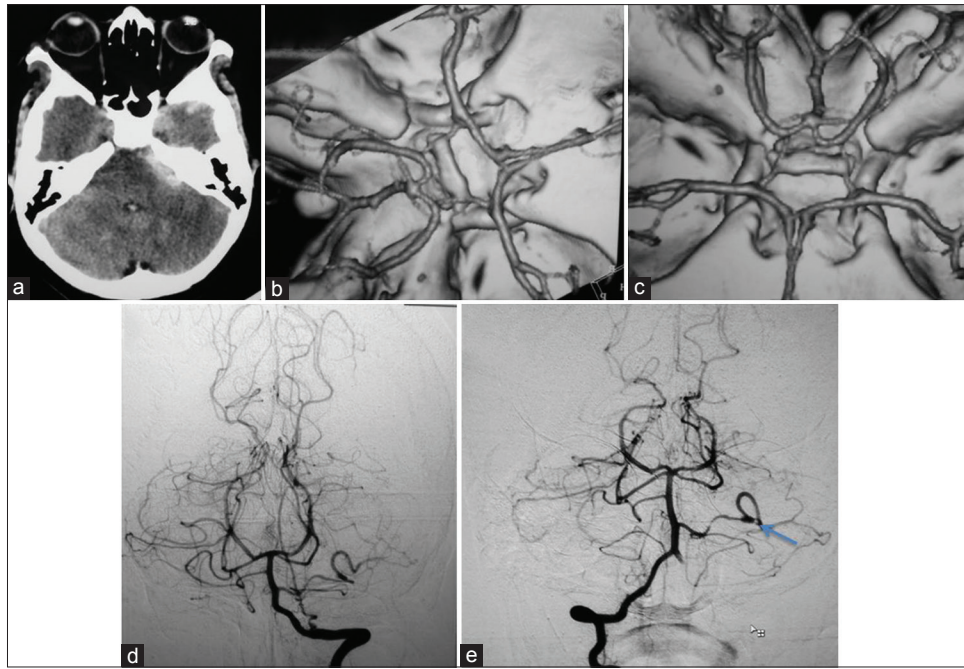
NCCT head showing moderate SAH in left cerebellopontine angle cistern (a), 3D-CTA brain showing no structural abnormality (b,c); Initial DSA Brain showing no aneurysm (d); Repeat DSA brain revealed a small AICA aneurysm (arrow) (e)
